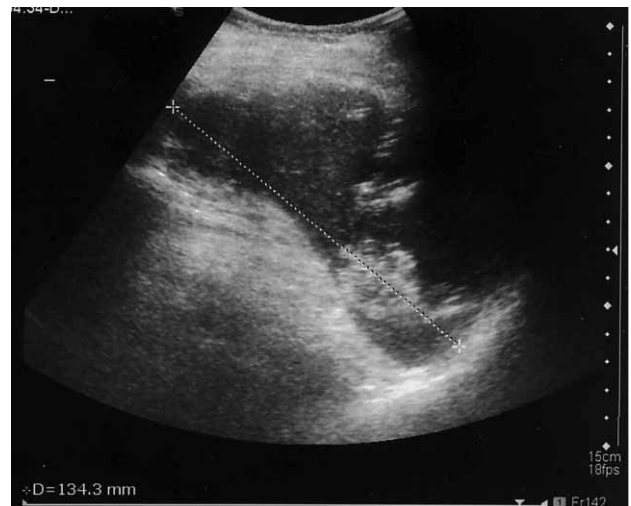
Ultrasonography of spleen: shows enlarged spleen with collection of necrotic material in the upper pole with the diameter of 13.4 cm.
